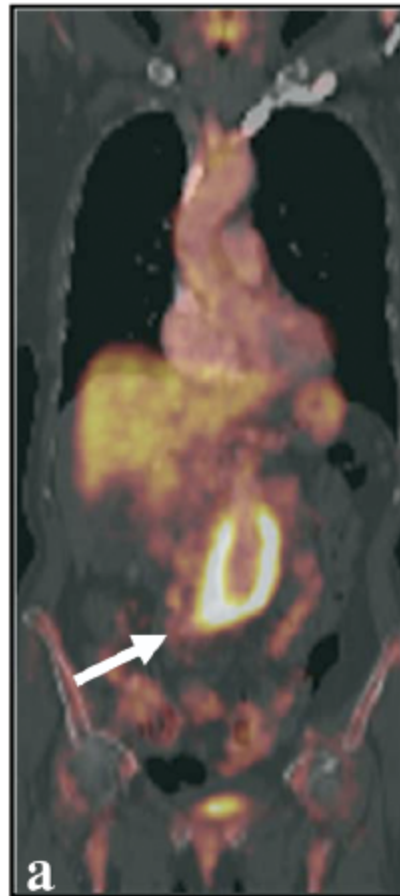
This painful rapidly expanding aneurysm of 70 mm displays 18-FDG uptake at the level of the aneurysmal wall.
